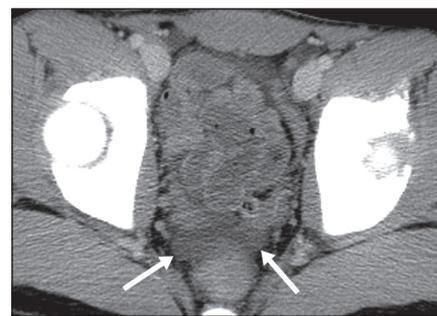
Free peritoneal fluid in absence of intraabdominal injury. Transverse CT image of male patient who sustained blunt abdominal trauma in motor vehicle accident shows small amount of low-attenuation (9 HU) free fluid in pelvis (*arrows*). CT examination did not show additional findings, and patient recovered without requiring any abdominal intervention.
